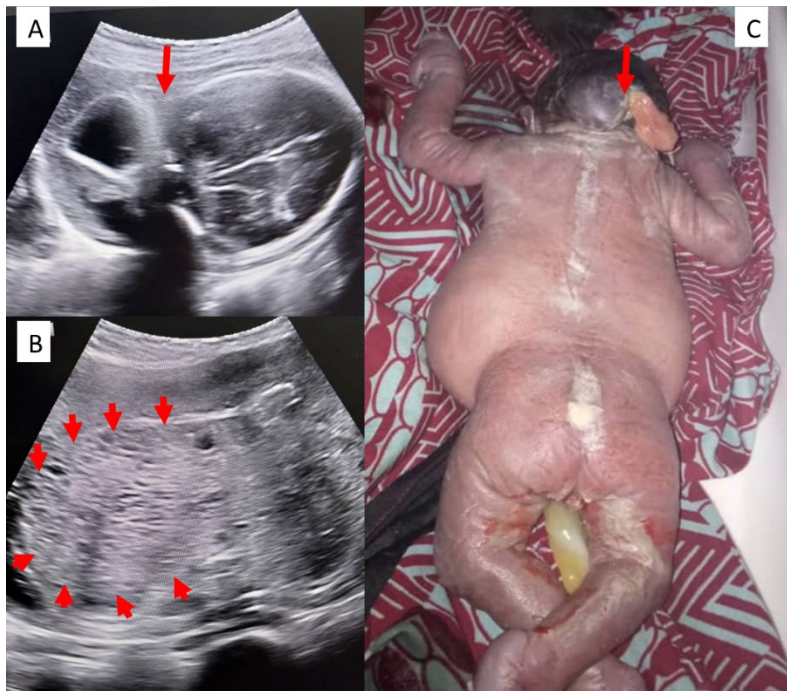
Antenatal ultrasound and posterior view photo of the newborn showing: (A) DRMK (arrowheads); (B) meningoencephalocele (arrow); (C) occipital mass corresponding to the meningoencephalocele.
